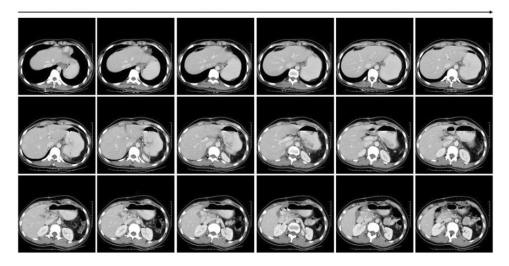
Six-month postoperative computed tomography images.
